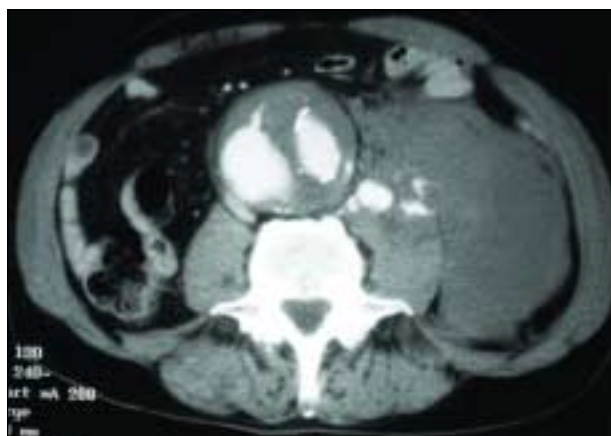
CT scan of a patient with a large retroperitoneal hematoma.
